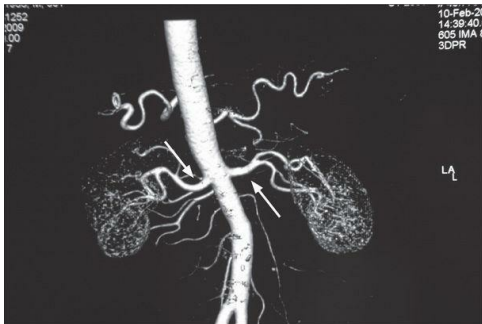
CT angiogram showing the origins and course of the renal arteries (large arrows) from the abdominal aorta; the left and right inferior phrenic arteries are visible arising superiorly
